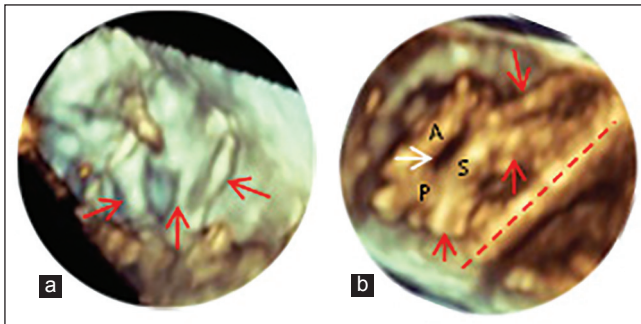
3D echocardiographic image (right ventricular view) of normal tricuspid valve (TV) chordae (a: Red arrows). Short, thickened chordae (b: Red arrows) that significantly tethered and decreased the mobility of the septal leaflet (red line runs along the ventricular septum) resulting in a large coaptation defect (white arrow) between the septal and anterior/posterior leaflets. A: Anterior leaflet, P: Posterior leaflet, S: Septal leaflet
